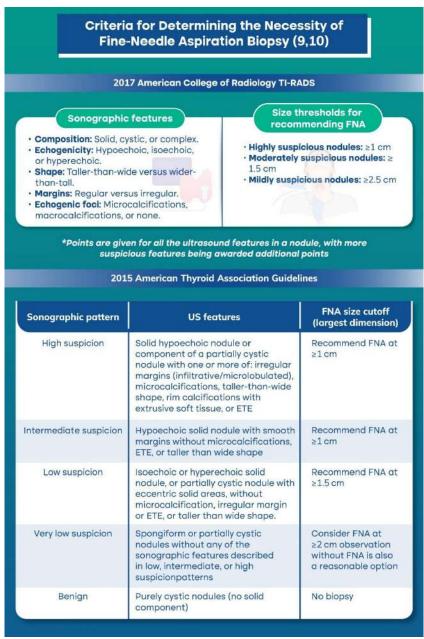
Criteria for FNA of thyroid nodules based on ultrasound features and size, per 2017 ACR TI-RADS and 2015 ATA guidelines (9,10)
